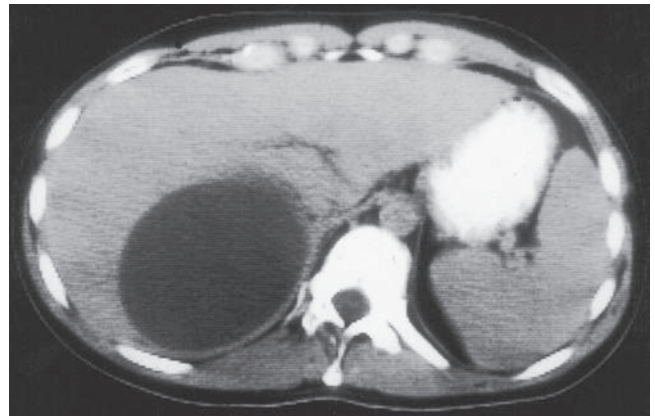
CT scan demonstrating a cystadenocarcinoma.
